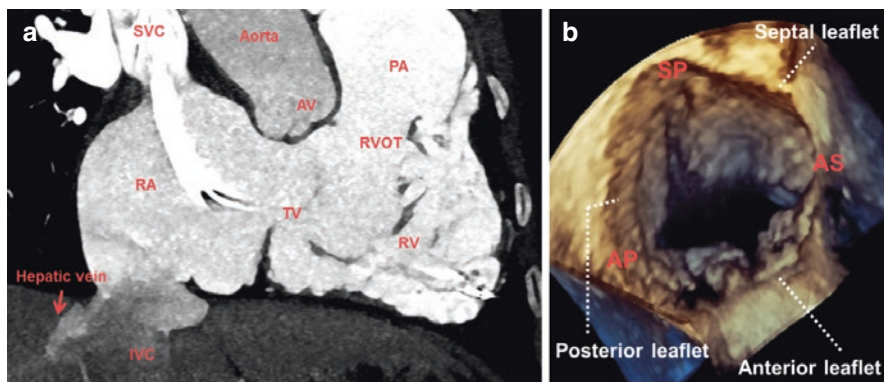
Imaging of the tricuspid valve. (a) Angio-computed tomography of tricuspid valve and right heart structures characterization for pre-procedural planning. *TV* tricuspid valve, *APC* antero posterior commissure, *ASC* antero septal commissure, *RCA* right coronary artery, *AV* aortic valve, *RA* right atrium, *RV* right ventricle, *SVC* superior vena cava, *IVC* inferior vena cava, *RVOT* right ventricular outflow tract, *Pa* pulmonary artery. (b) Identification of TV leaflets and localization of the each commissures with tree dimensional transesophageal echocardiography; *SP* septoposterior, *AS* anteroseptal, and *AP* anteroposterior, commissures
